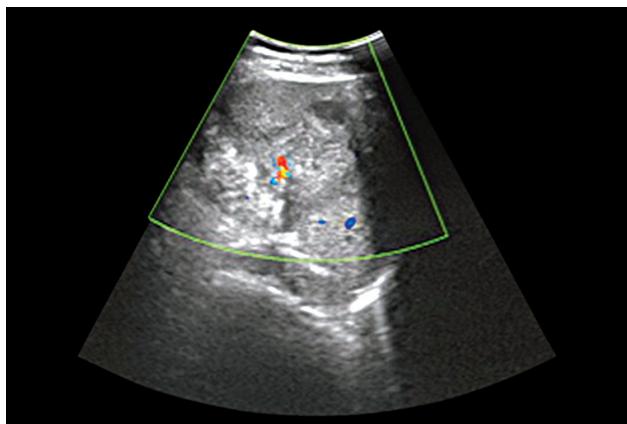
Transabdominal ultrasound showing a heterogeneous and vascularized mass with a predominantly solid component.
